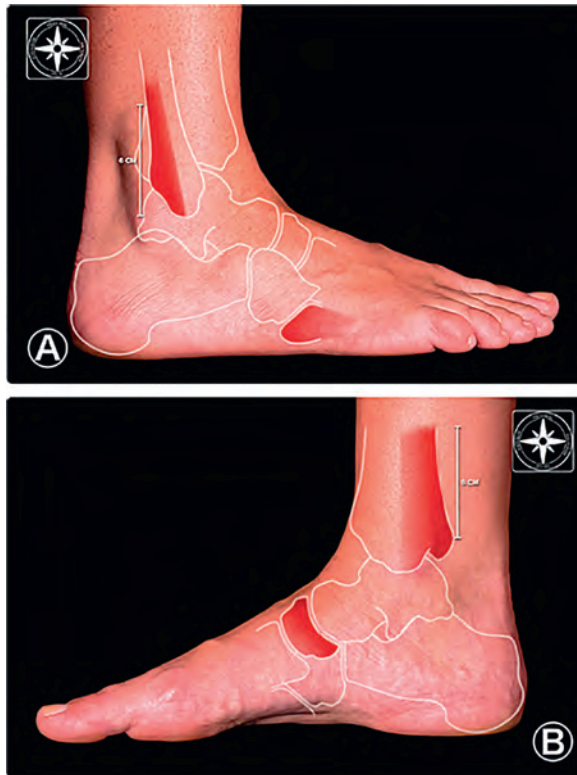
Ottawa foot and ankle rules. X-ray is required only if there is any pain in the areas identified in red color. A) Lateral view. B) Medial view (Image processed by Dr. Pau Golano⁵)
